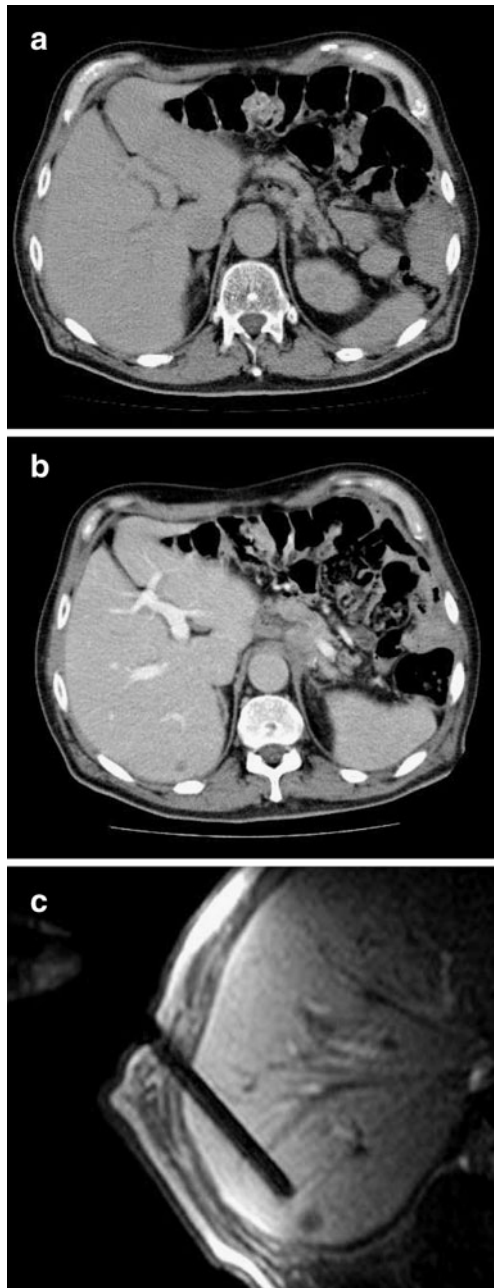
Negative plain CT (a) as it would be used for CT intervention. Contrast-enhanced diagnostic CT confirms a small colorectal liver metastasis (b). The corresponding Gd-EOB-DTPA enhanced MR fluoroscopy (c) clearly depicts the lesion during the procedure
